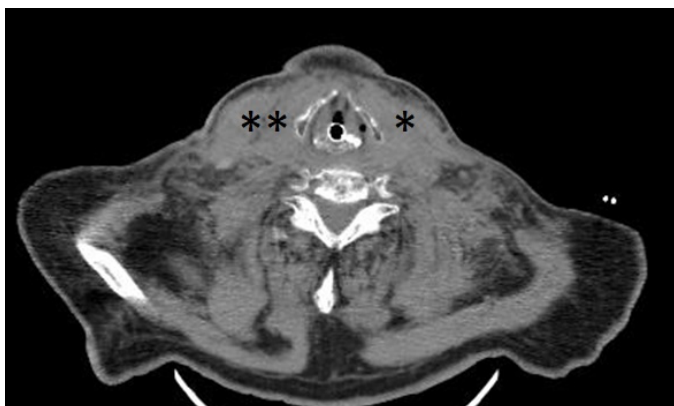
The transverse section of the neck CT of the patient is demonstrated. Hyperdense areas in keeping with hematoma is noted in both sides of the neck (asterisks). Besides, heterogeneous dense in the subcutaneous and deep fat planes in the neck are noted due to edema
